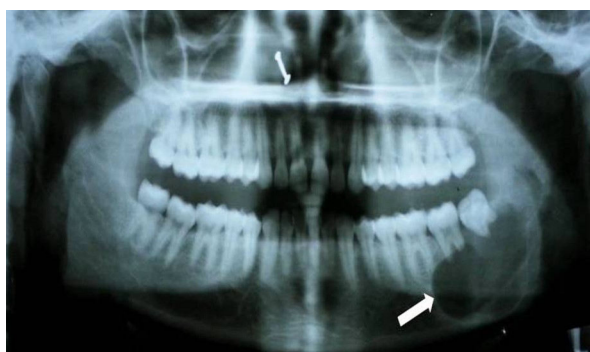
Preoperative, orthopantomogram (OPG)
